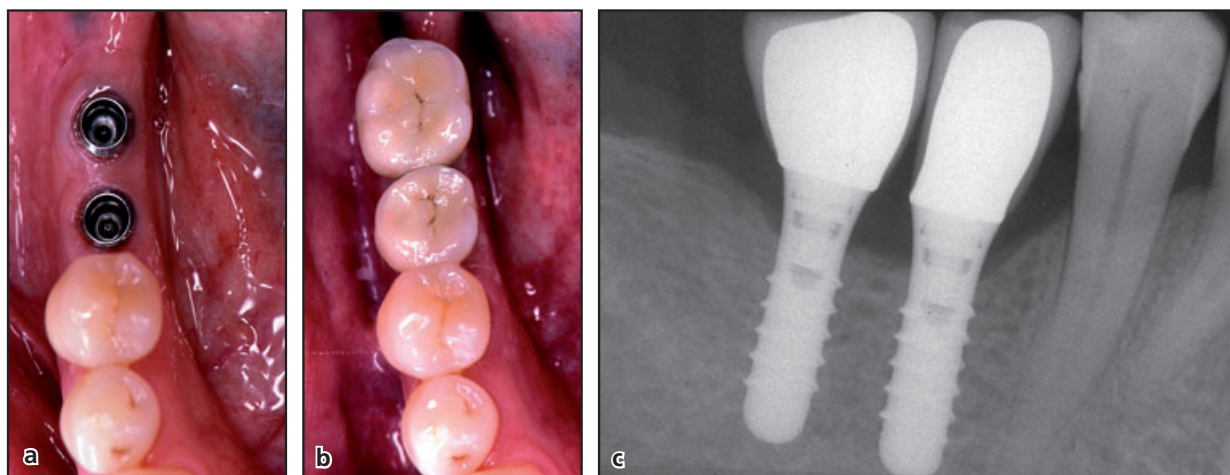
Increasing subjective chewing comfort by replacing missing teeth in a free-end edentulous situation. (a) Installation of two standard size (4.1 mm diameter) Straumann® implants (10 mm), 5 and 11 mm distal to the distal aspect of tooth 45. (b) Chewing units are replaced as a premolar on implant in position 46 and a molar in position 46/47. (c) Radiographic view 5 years after the reconstruction.
